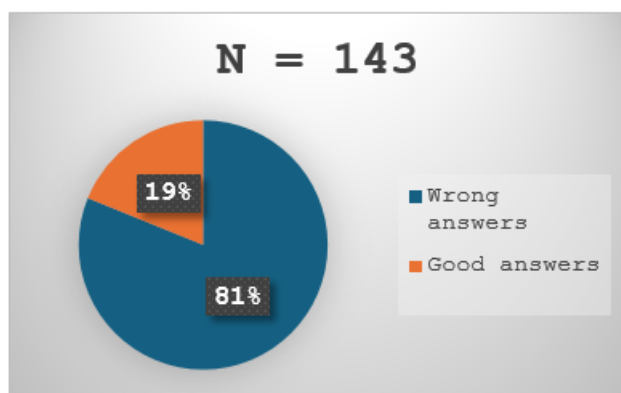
Prescribers' knowledge of how X-ray risks arise
